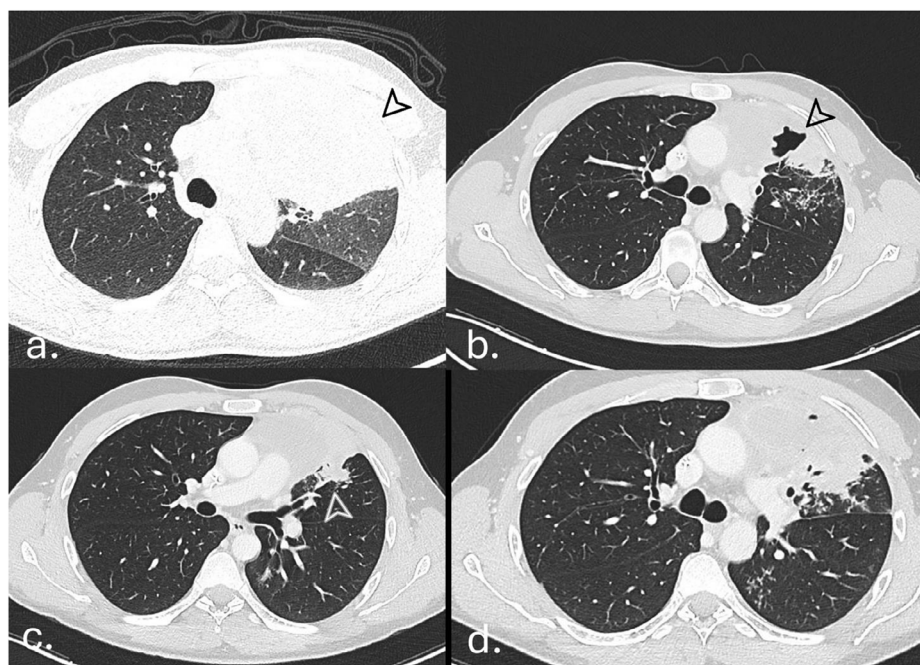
CT scan showing the mediastinal mass of DLBCL before (a), during (b), and after first-line (c) and second-line (d) chemotherapy. The lesion was in the mediastinum, but as it was very close to the upper left lobe, on imaging it was not always very clear if the lung was involved or not.
